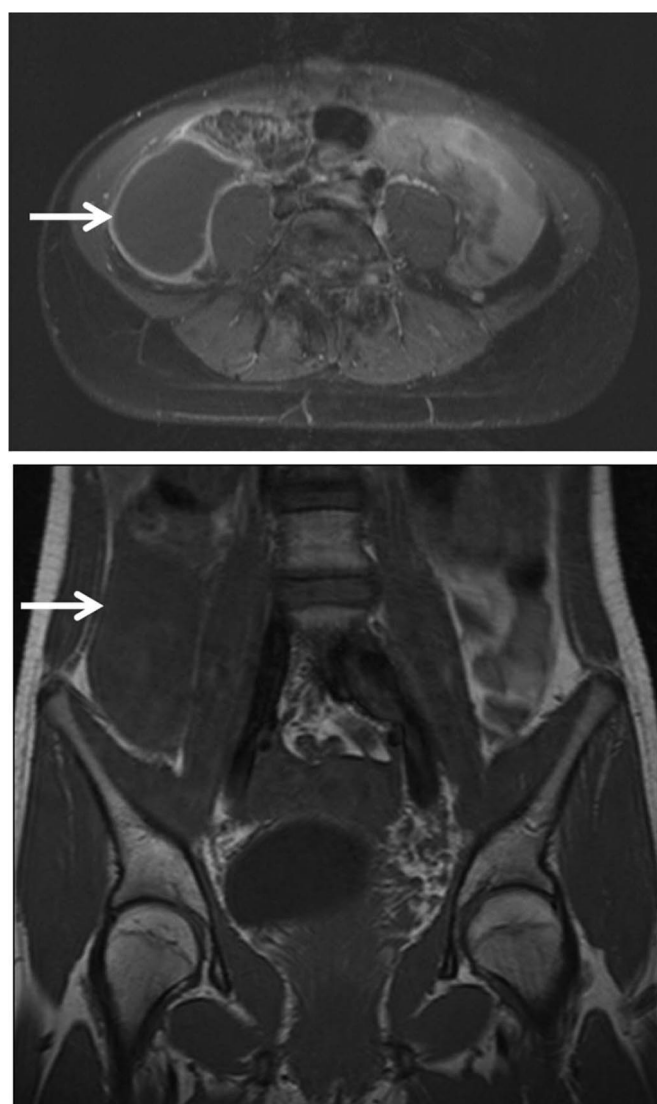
Magnetic resonance imaging demonstrating the right paracolic localization of the peritoneal inclusion cyst (arrow); axial view (top) and coronal view (bottom).
